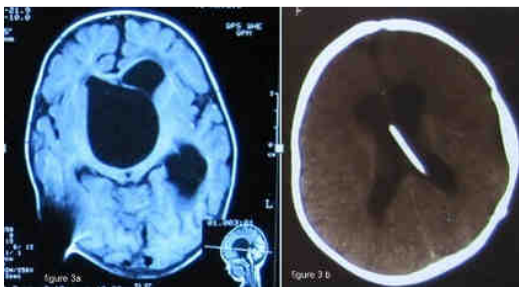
Pre-operative CT brain of 8 years female having suprasellar arachnoid cyst presented with vomiting, headache and diminution of vision. Figure 3b - CT brain of post-cystoperitoneal shunt showing reduction in size of suprasellar arachnoid cyst
